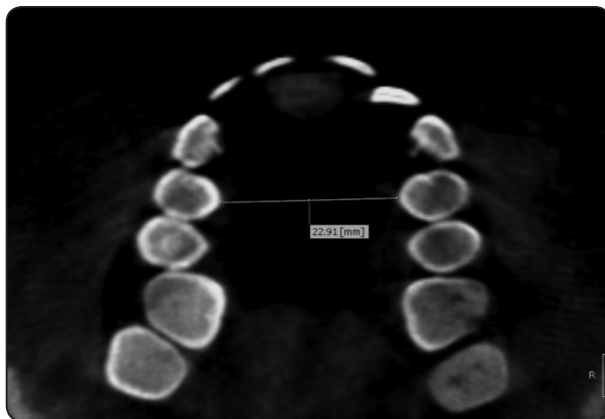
Axial CBCT image showing measurement of intra-arch distance.
